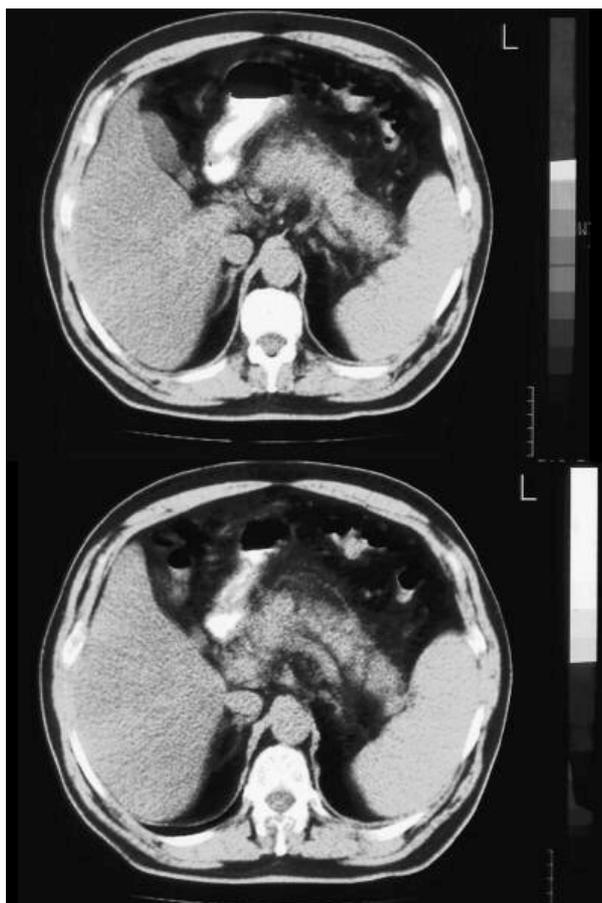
CT scan of the abdomen showed moderate pancreatic edema.
